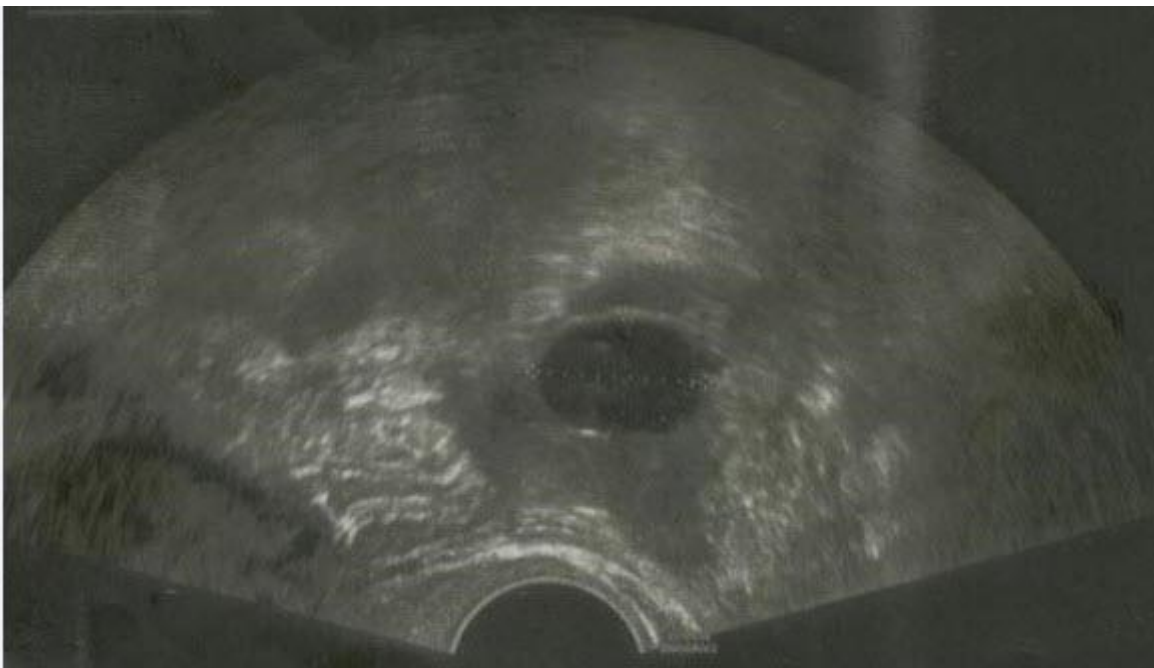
Ultrasound of the patient
